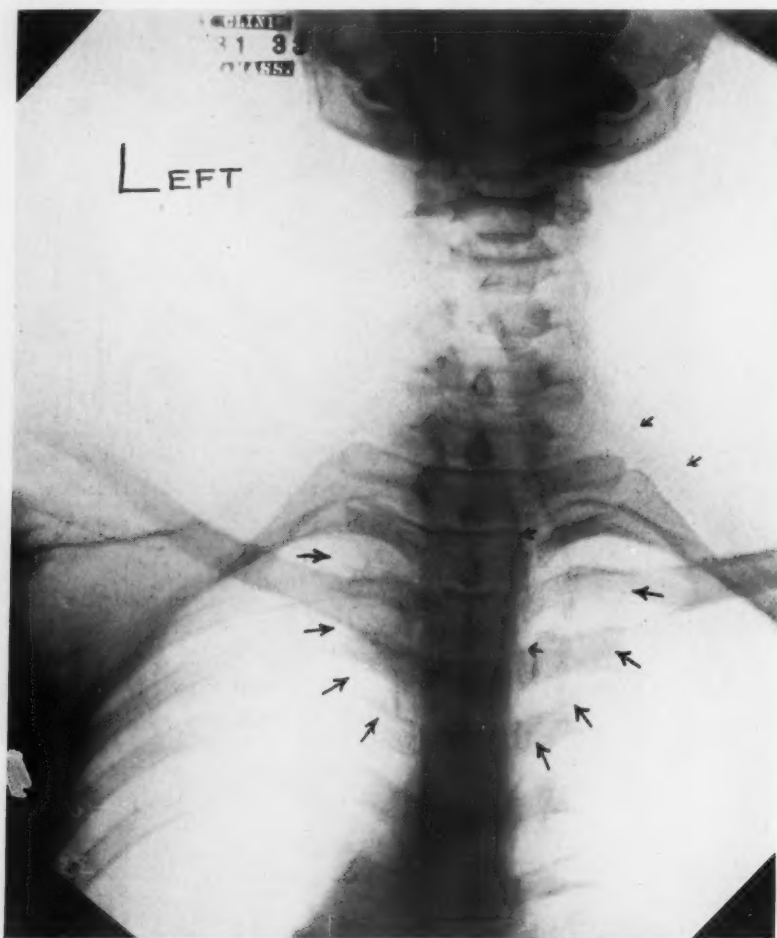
X-ray of large bilateral goitre deeply intrathoracic on left. (No. 32760.) Shadow of right goitre above clavicle and left goitre below clavicle causing obstruction chiefly of left innominate vein.
